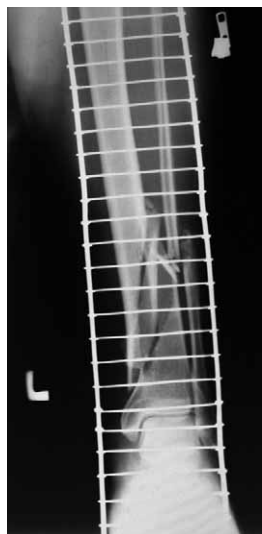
A-P projection X-ray of the left tibial shaft after injury.
